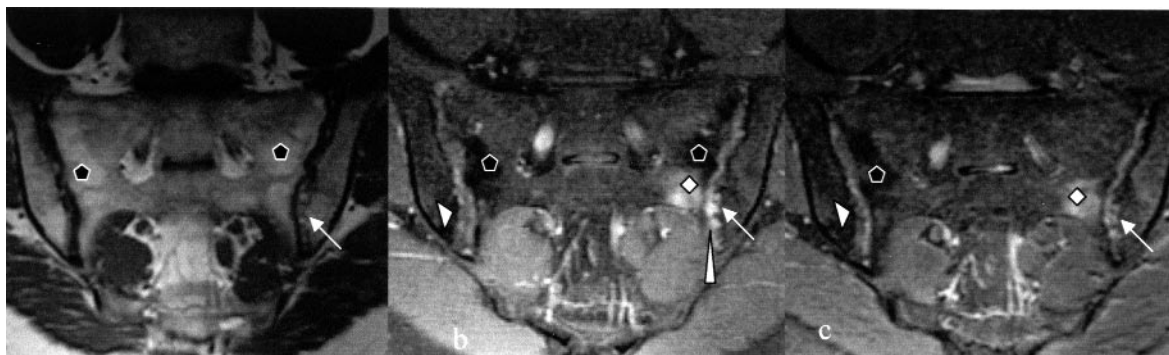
Coronal MRI examination of the sacroiliac joint in a 43-year-old patient with AS. Fat inflation (◆) is visible on SE T1, FS T1-weighted post-contrast (b) and FS T2-weighted images (c), on both sacral and iliac sides (a). Cartilage lesions (V) and erosions (Λ) were scored on FS T1-weighted post-contrast (b) and FS T2-weighted images (c). Concerning inflammatory criteria, bone marrow edema is present on the sacral side of the synovial site (◇) on T1-weighted postinjection and T2-weighted images. Synovitis (Δ) is localized in the inferior part of the left sacroiliac joint on FS T1-weighted postcontrast images (b).
